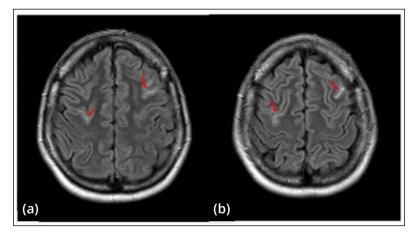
Skull MRI image: Presence of discrete hypersignal on FLAIR in some cortical sulci, predominating in the bilateral frontal region, as demonstrated by arrows in images (a) and (b).
